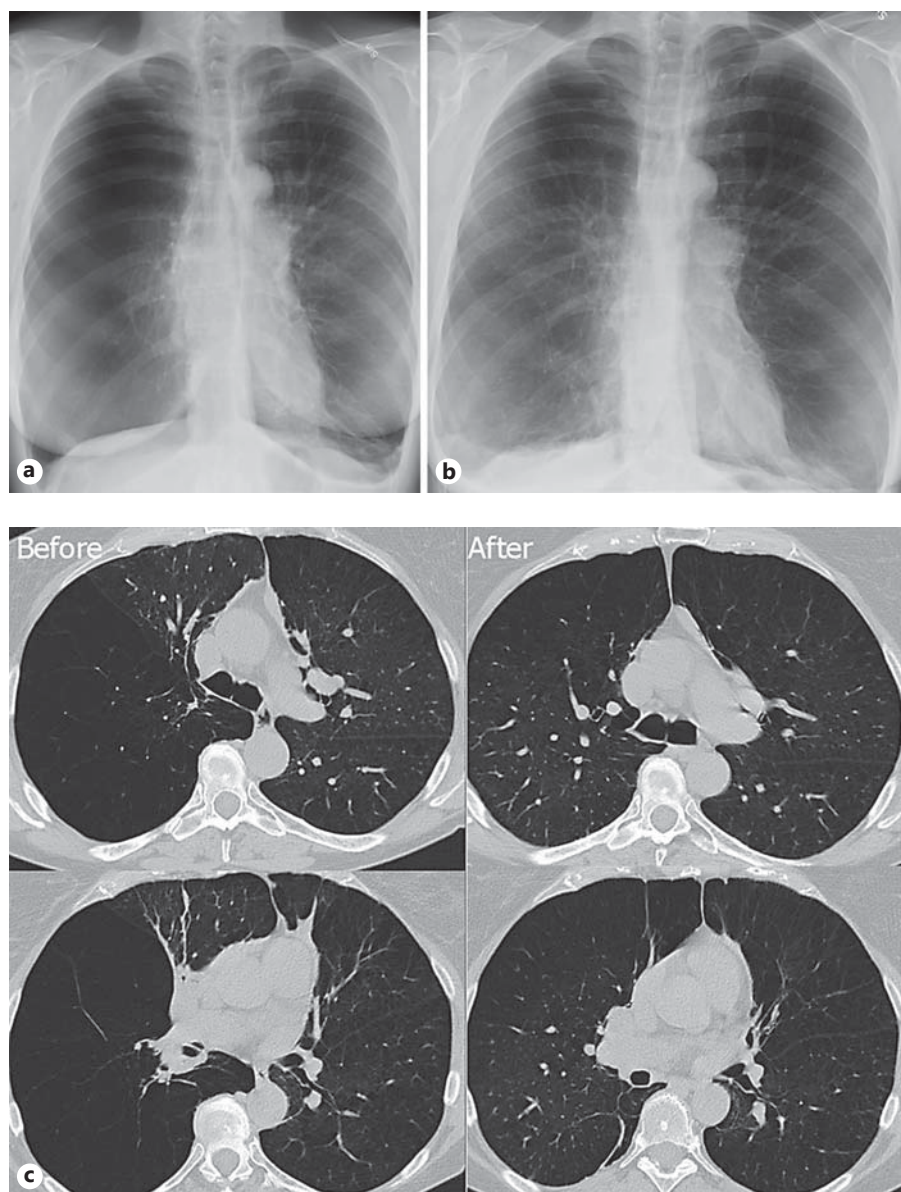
Patient 1. Chest roentgenogram before (a) and after (b) ELVR of the right lower lobe. c CT slides before (left column) and 6 months after ELVR (right column).
